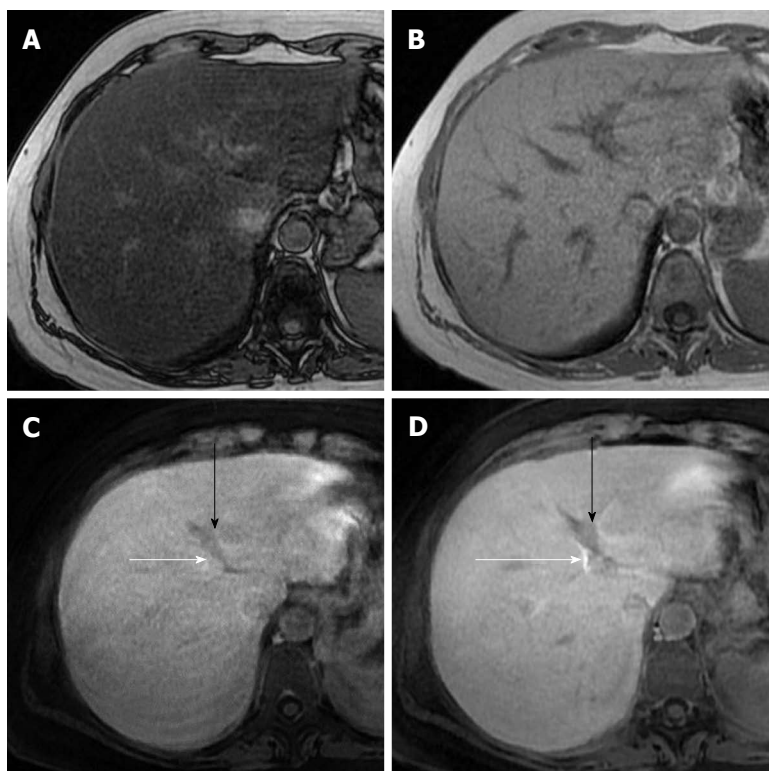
Reduced hepatobiliary phase enhancement due to severe hepatic steatosis in a 42-year-old woman with hepatitis C virus-related chronic hepatitis. A, B: T1-weighted gradient-echo images show diffuse signal intensity decrease of the liver on out-of-phase (A) image compared with that on the in-phase image (B), indicating severe hepatic steatosis; C: On 10 min hepatobiliary phase, gadoteric acid enhanced magnetic resonance imaging, left portal vein (black arrow) shows iso- to hypointensity to liver parenchyma; D: On 20 min hepatobiliary phase left portal vein shows slight hypointensity to liver parenchyma. Enhancement of bile ducts (white arrows) is less intense on 10 min hepatobiliary phase than that on 20 min hepatobiliary phase, indicating delayed biliary elimination of gadoteric acid.
